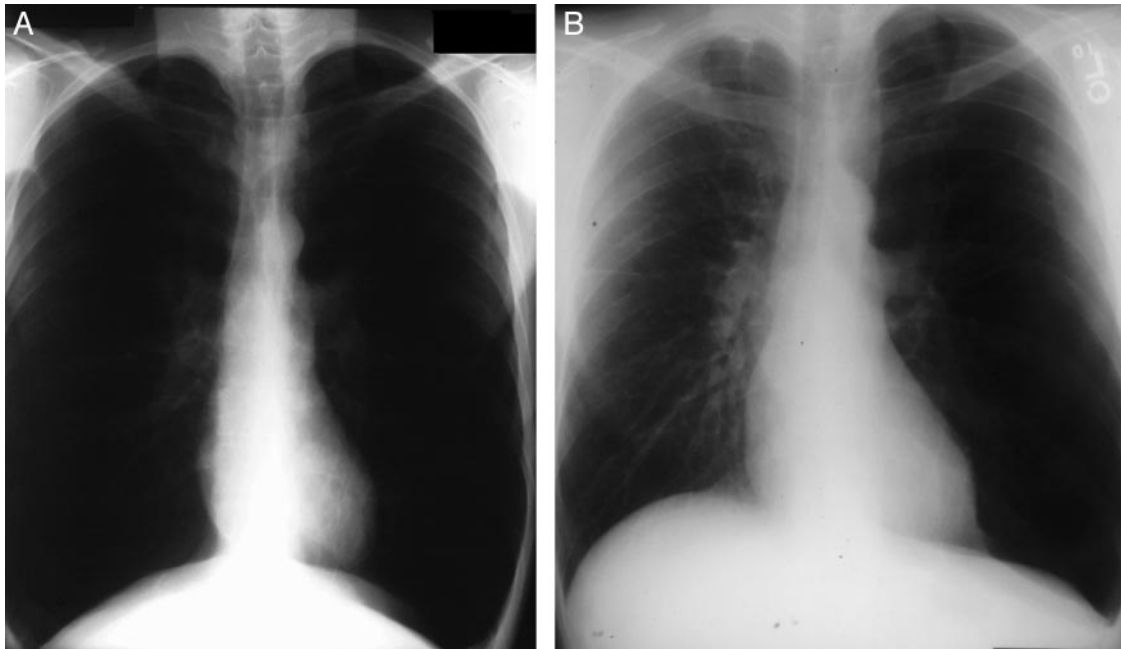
Posteroanterior chest radiograph of a patient with emphysema before (left) and after (right) a right-side single-lung transplant procedure.
